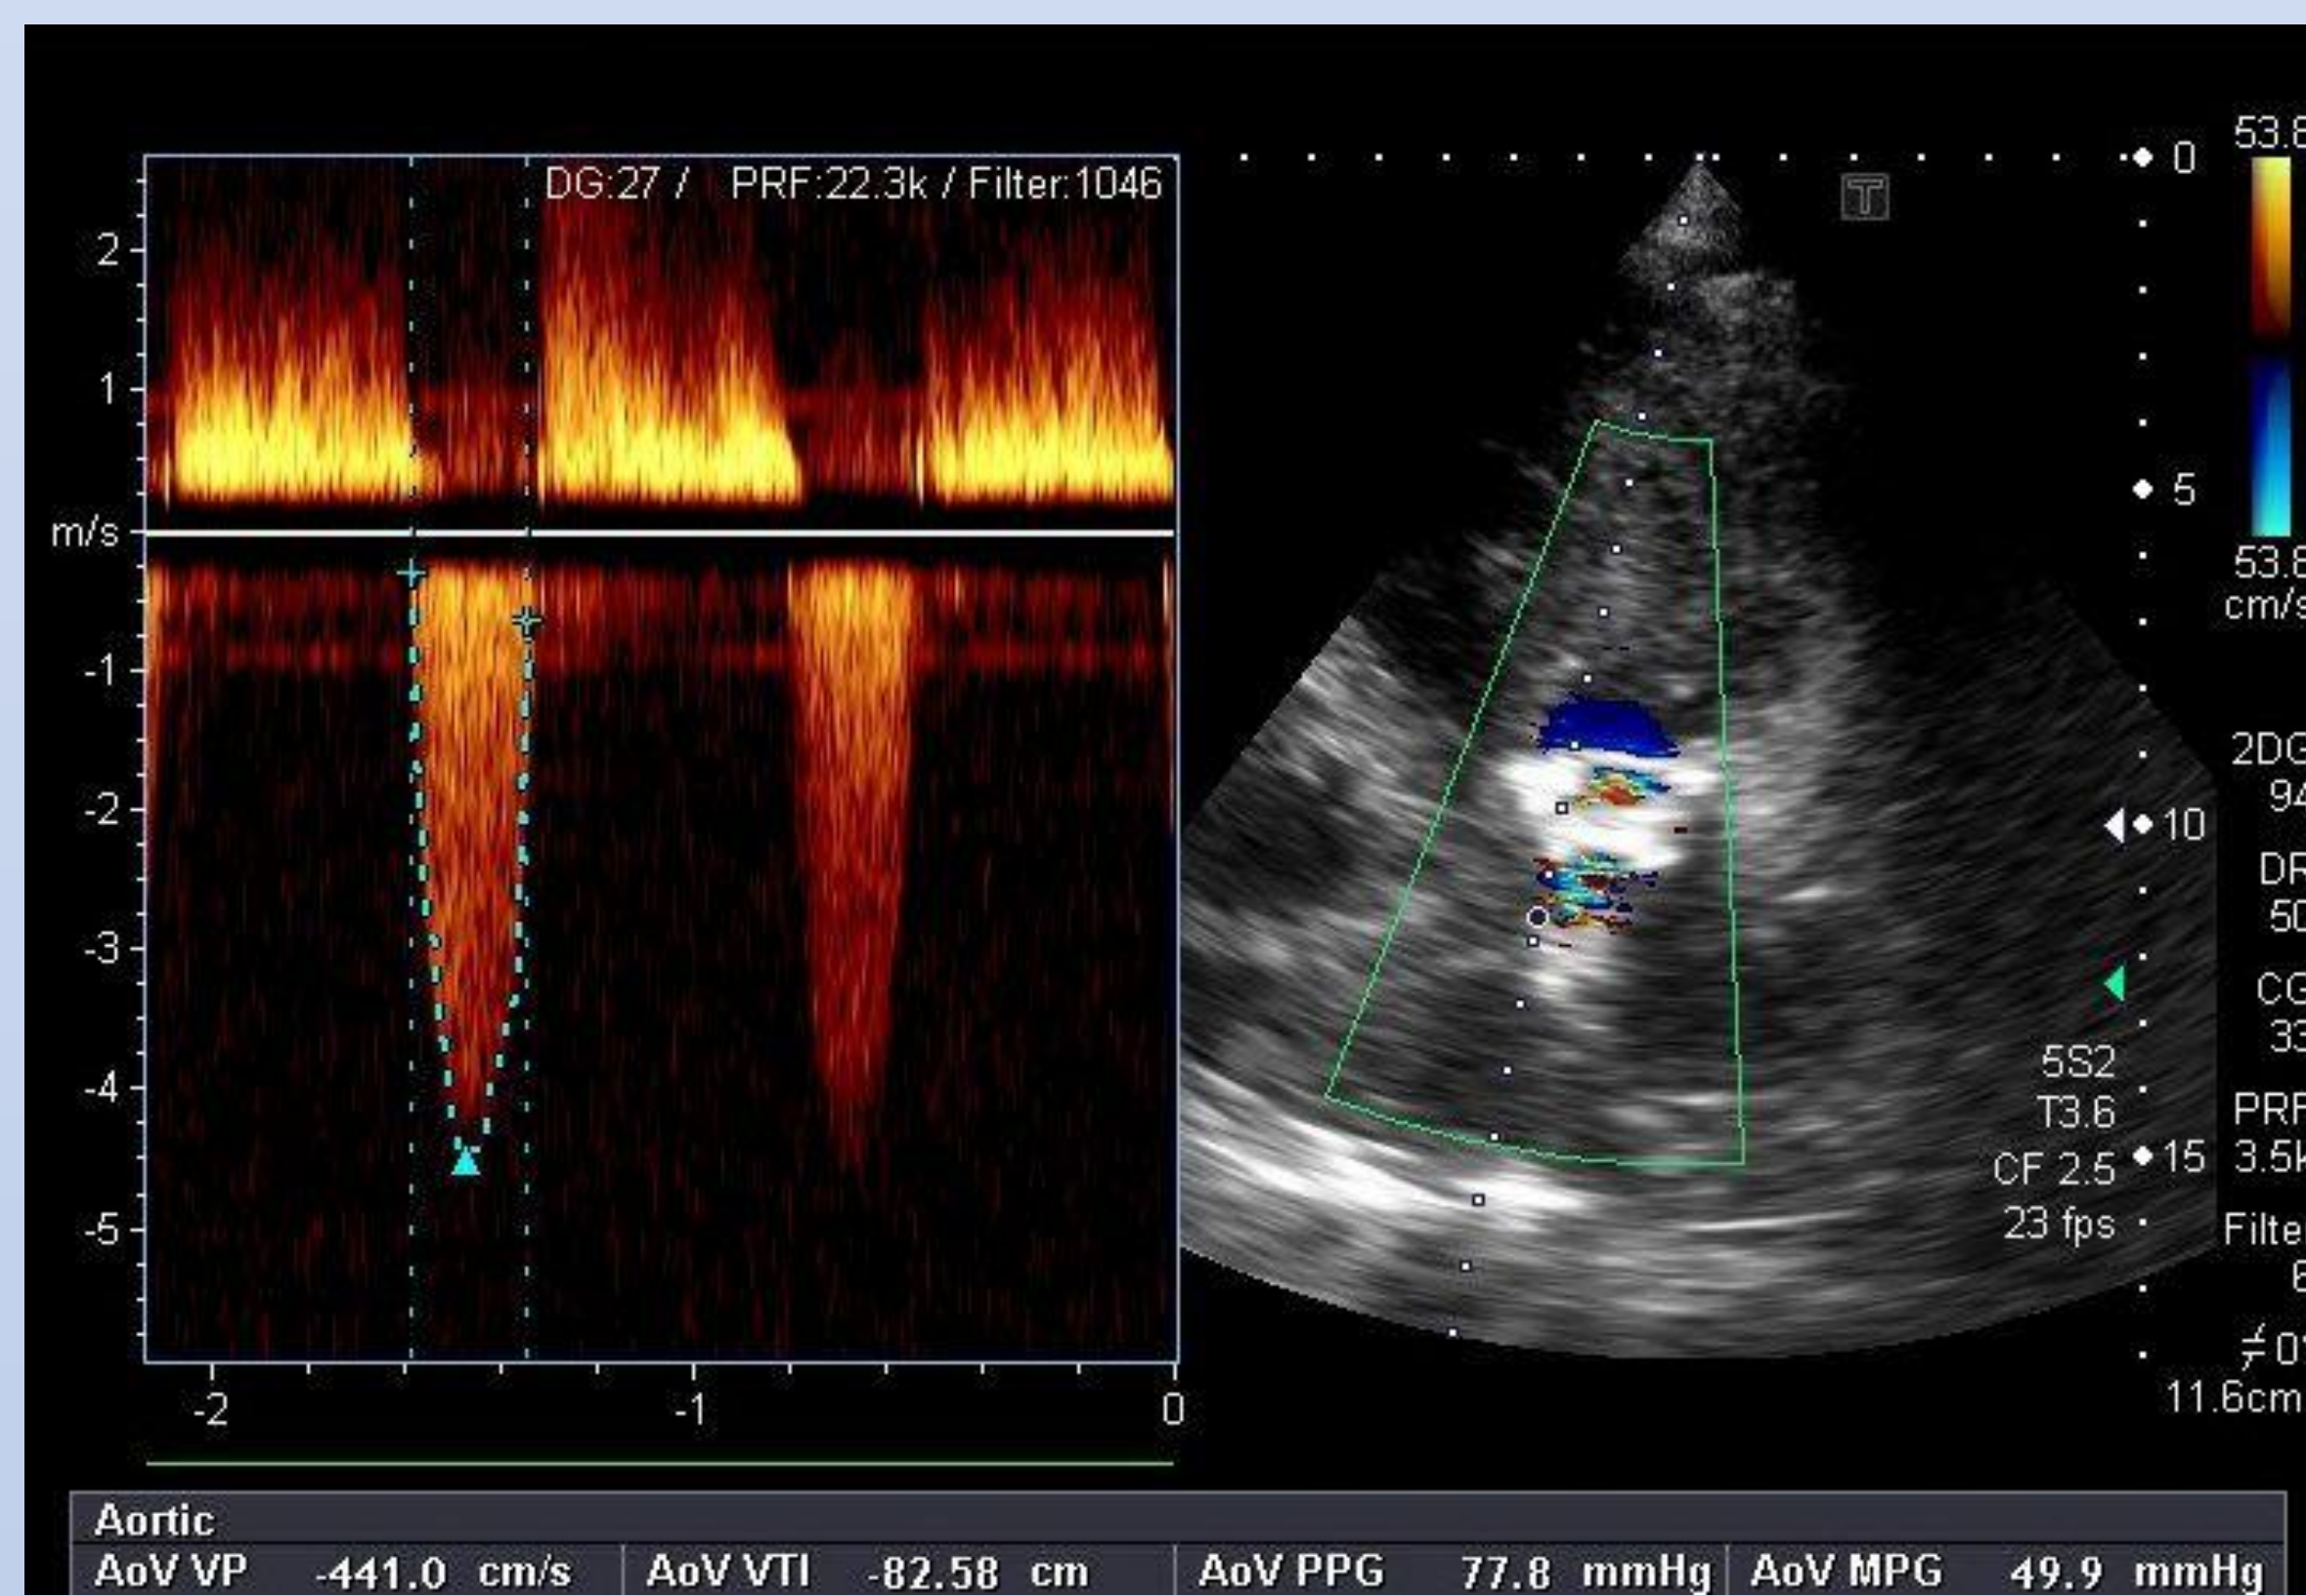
The pre TAVI echocardiography of the patient
